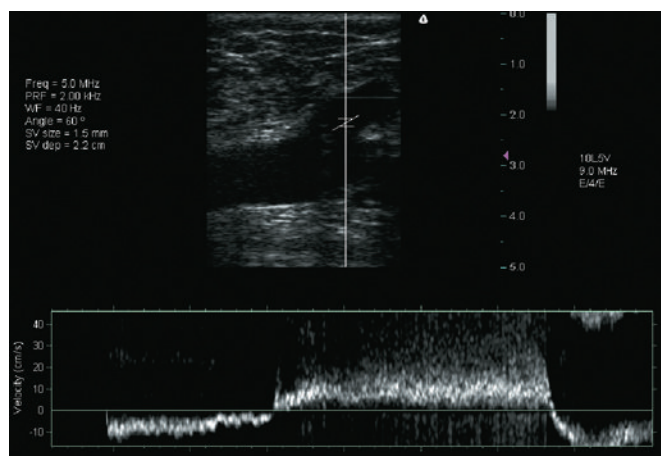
Duplex image showing reflux by pulsed-wave Doppler lasting more than 3 seconds. (Taken with Terason 2000 system.)
